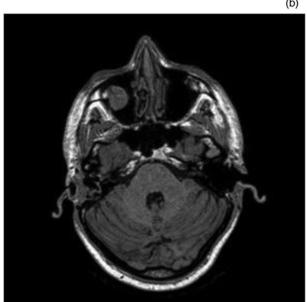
(a & b) Pre-operative axial magnetic resonance imaging scans, showing erosion of the facial nerve on the left side.
